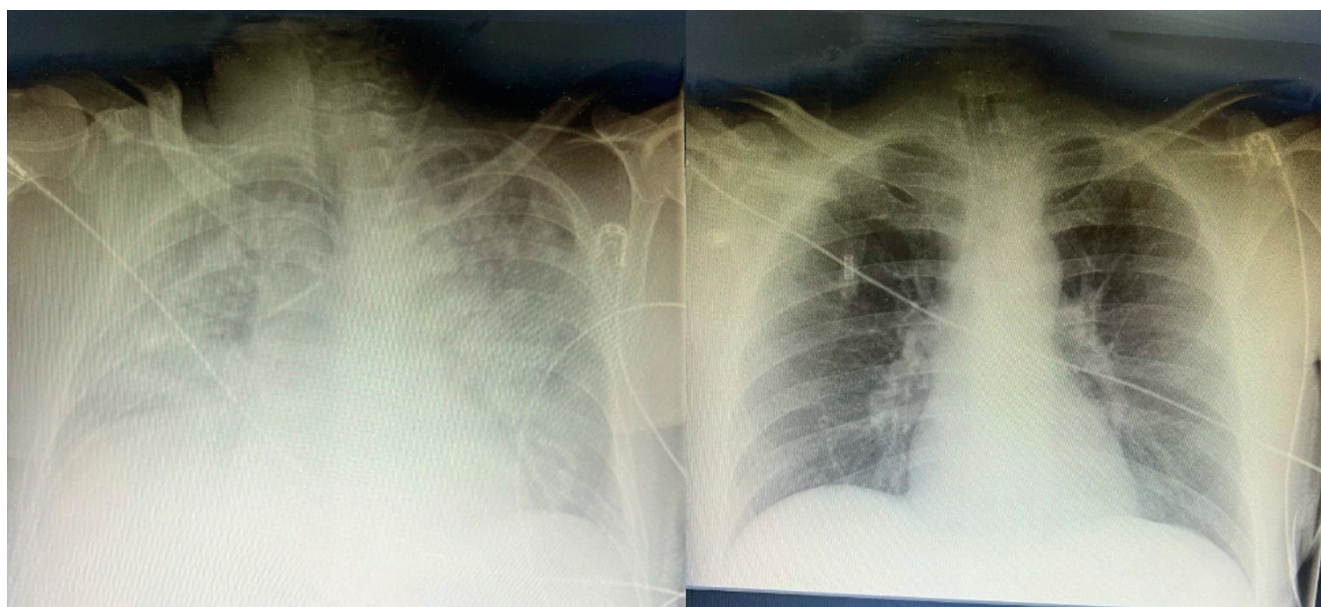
Chest x-ray before and after prone position
